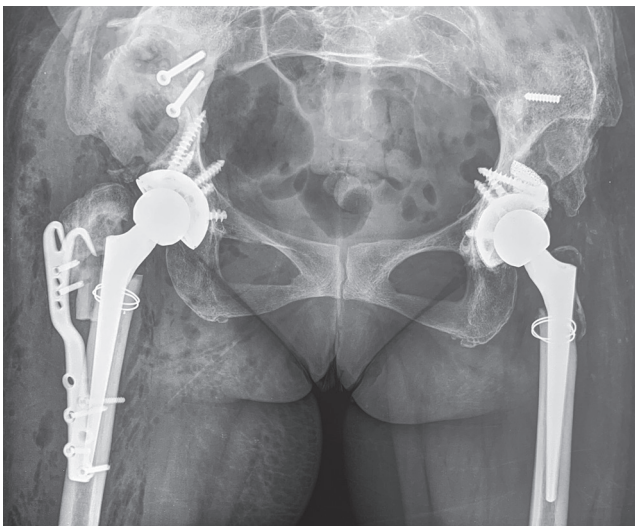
The frontal X-ray of a 46-year-old female patient the day after the revision.
